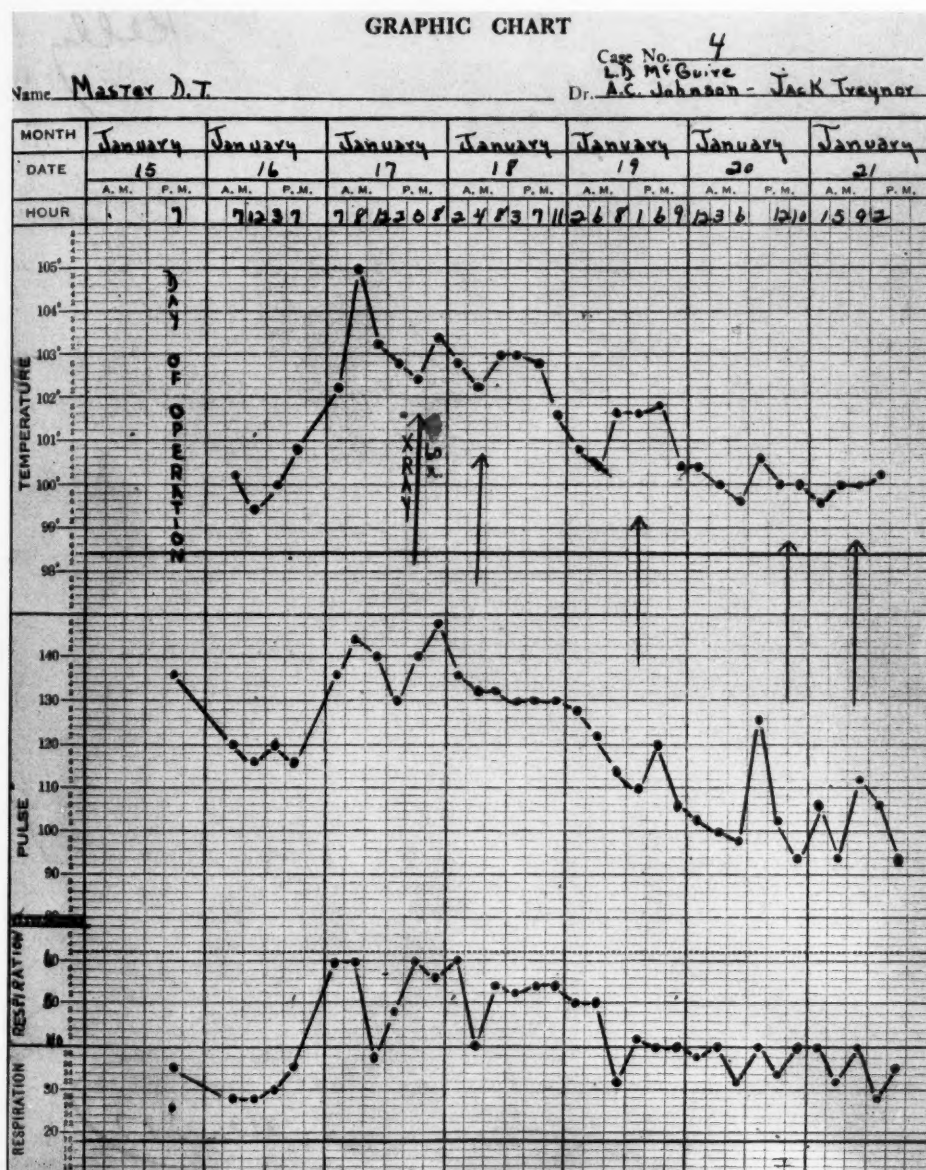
Case 4. Diagnosis: lobar pneumonia, Type III. X-ray technic: kv. 110; ma. 5; distance 50 cm.; filter 3 mm. Al; r units, 60 per treatment, total 300; port, chest anteriorly; result, excellent.
